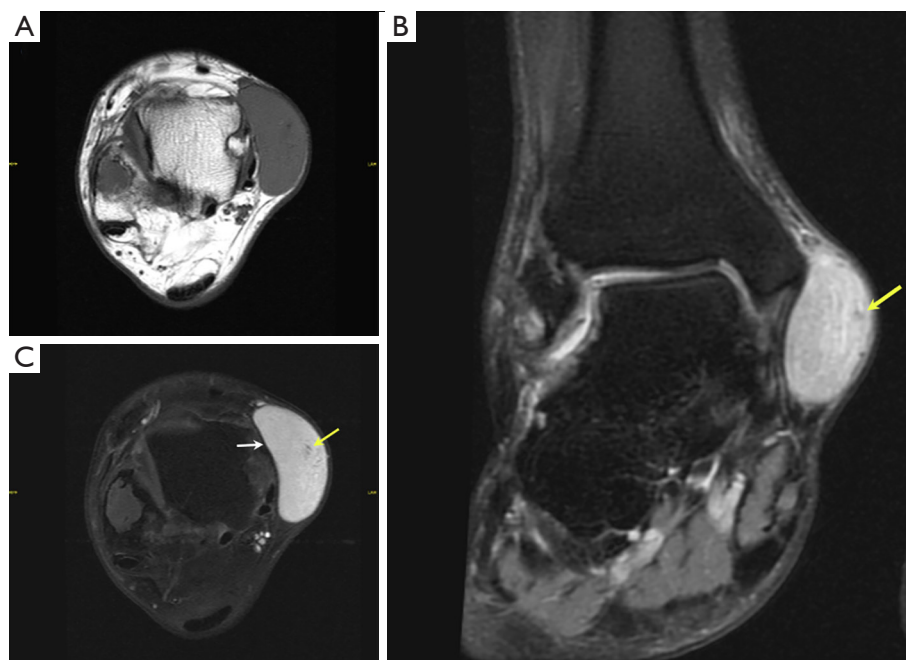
MRI images of a 43 years old male with a subcutaneous ankle angioleiomyoma. (A) Axial SE T1. A well defined subcutaneous tumor with a low signal intensity background. (B) Coronal FSE PD with fat suppression. High signal intensity background and thin signal voids (yellow arrow) corresponding to the dark reticular pattern. (C) Axial SE T1 fat suppression post-gadolinium. Tumor enhancement with a thin hypointense capsule (white arrow) and the characteristic dark reticular pattern (yellow arrow). MRI, magnetic resonance imaging; SE, spin-echo; FSE, fast spin-echo; PD, proton density.
